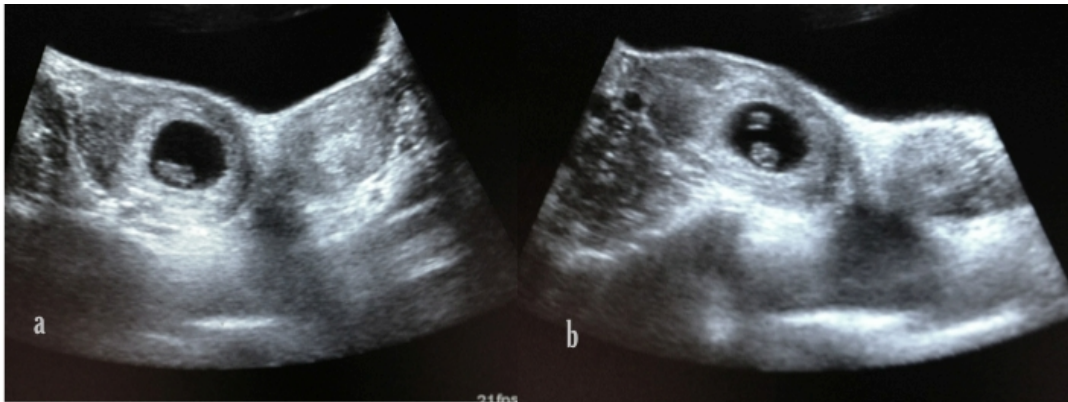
Ultrasound images of 23 years old female with uterine didelphys who came with 6 weeks amenorrhea. Single intrauterine gestational sac was seen in right uterine body. Fetal pole and yolk sac was seen
